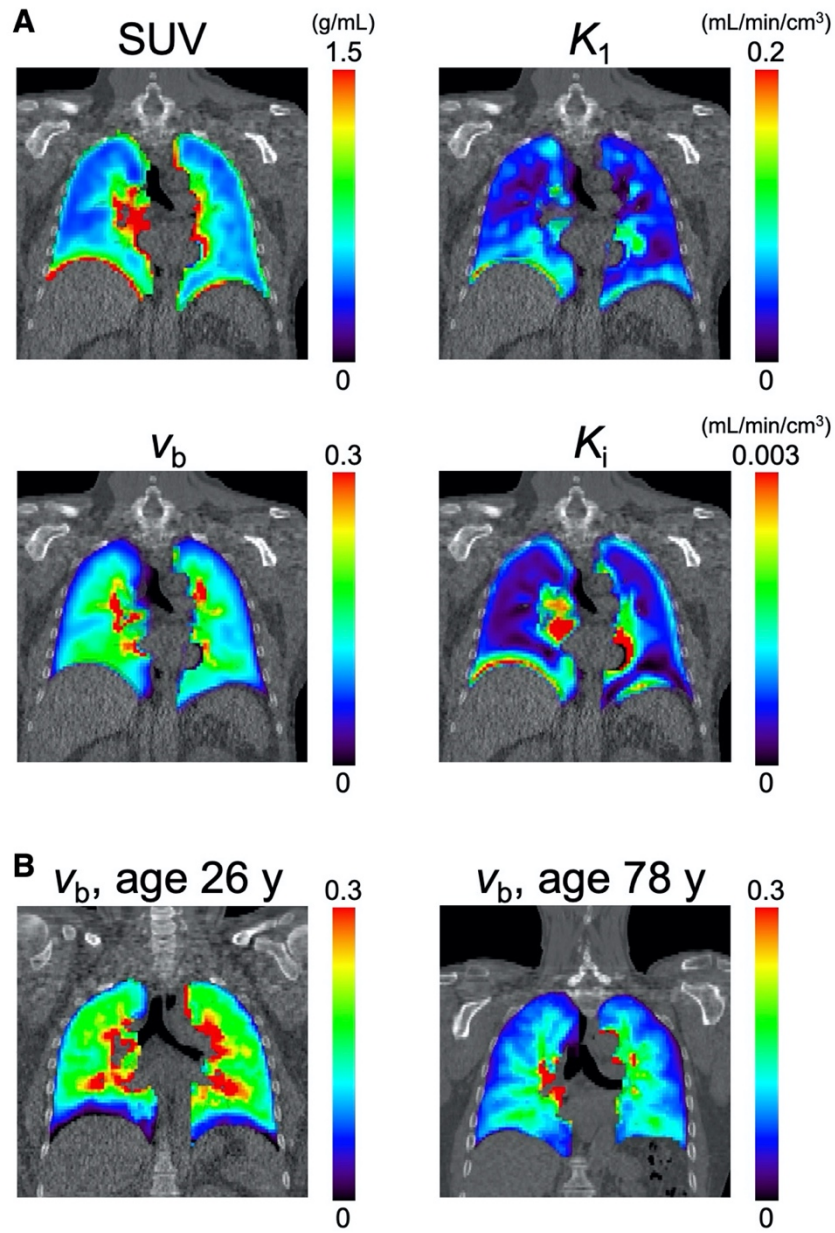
(A) ^{18}F -FDG PET images of the segmented lung for an example subject (#4): SUV image of 55-60 min, and multi-parametric images of ^{18}F -FDG delivery rate K_1 , fractional blood volume v_b , and net influx rate K_i generated with the IDIF-T-D model. These images are superimposed on the corresponding CT images. (B) v_b images of a young subject (age 26 y, #3) and an old subject (age 78 y, #1).
